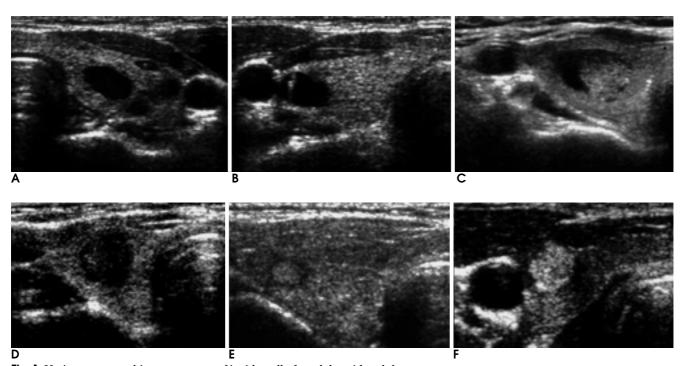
Various sonographic appearances of incidentally found thyroid nodules
